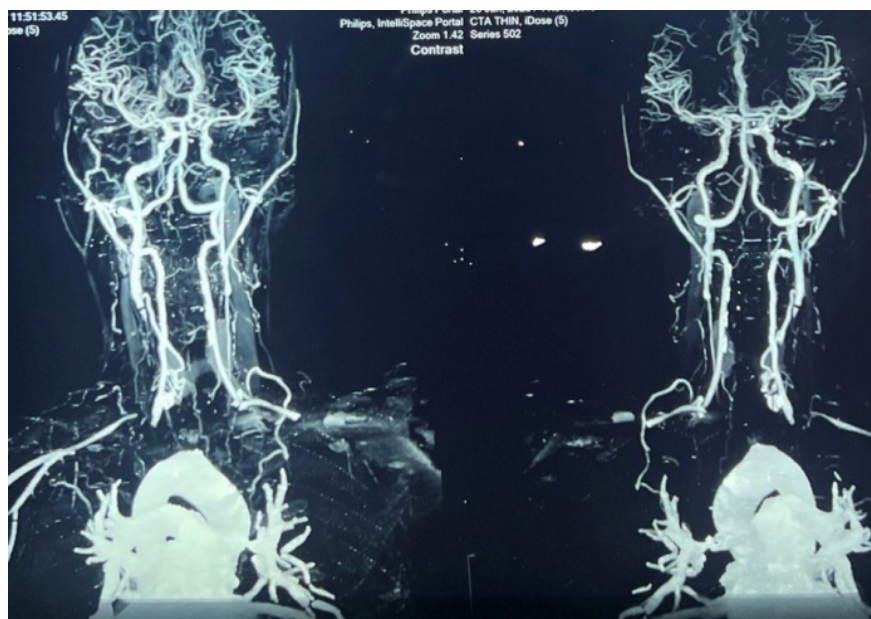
Computed Tomography (CT) angiography of the aorta and its branches showing diffuse symmetrical circumferential arterial thickening of the ascending aorta, aortic arch, and their branches, with significant luminal narrowing, consistent with Takayasu arteritis.
